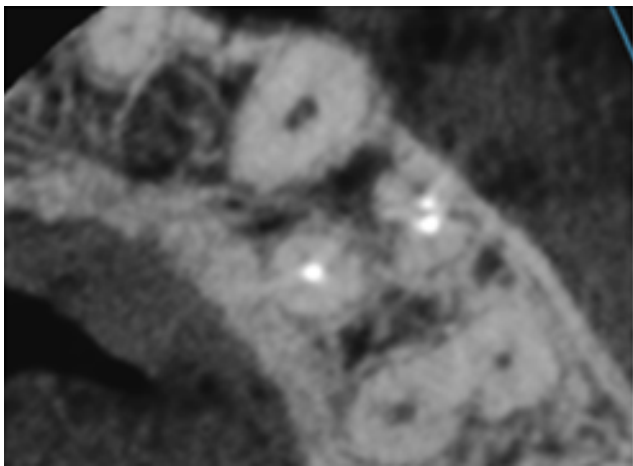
Post op CBCT with fused roots and 2 buccal canals
